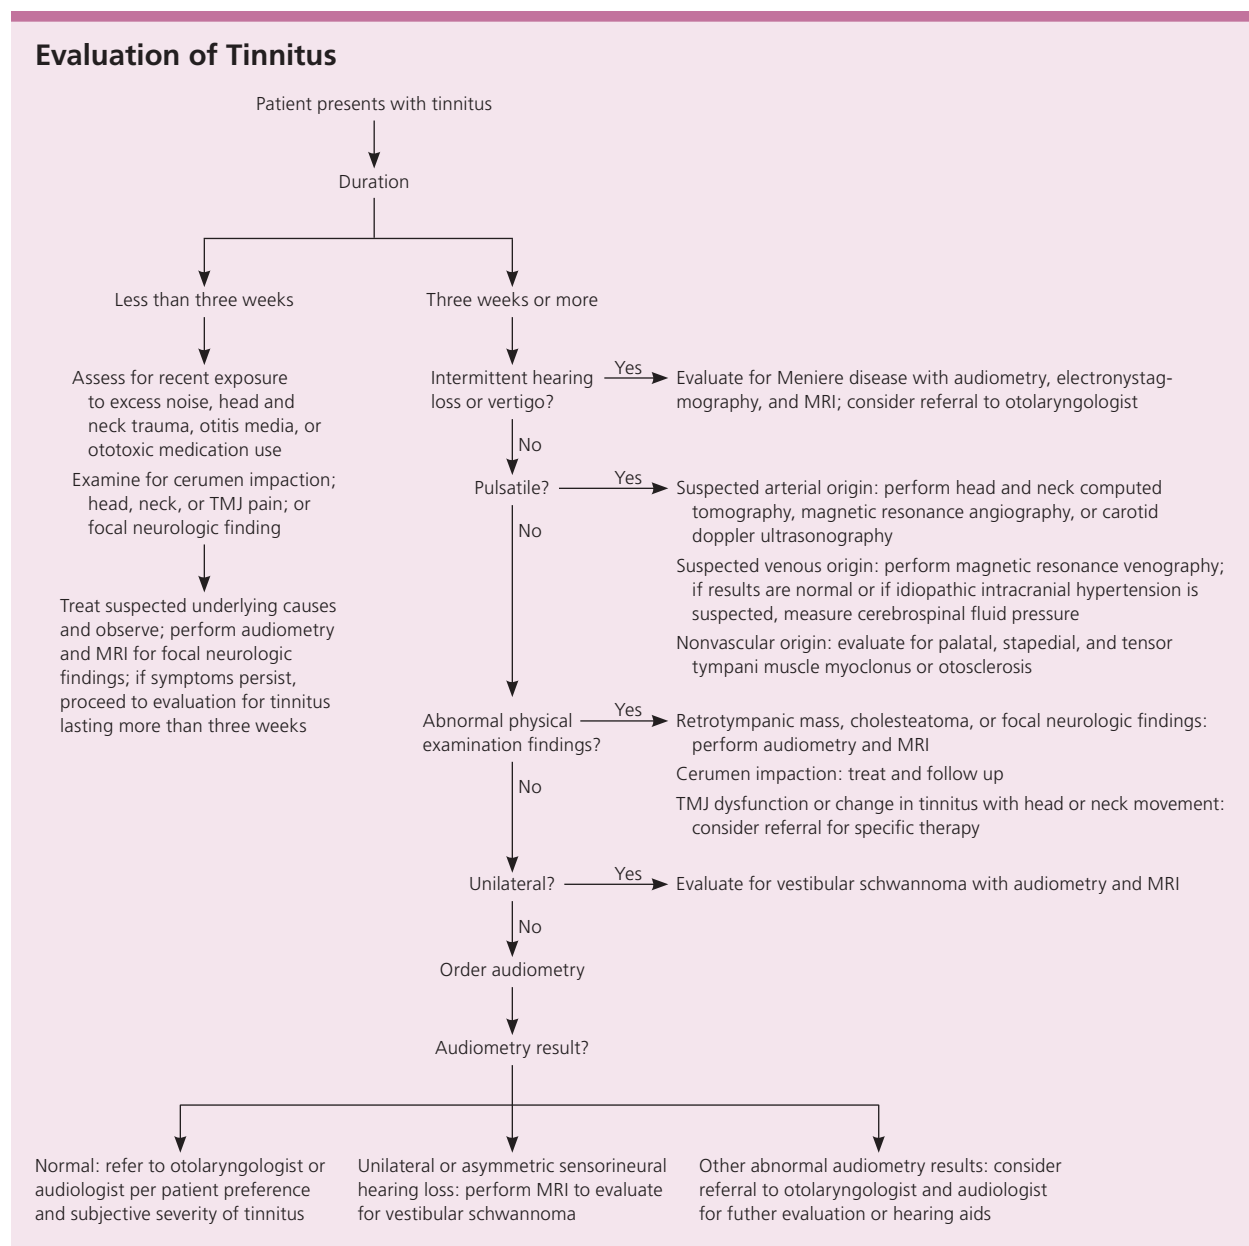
Algorithm for the evaluation of tinnitus. (MRI = magnetic resonance imaging; TMJ = temporomandibular joint.)
